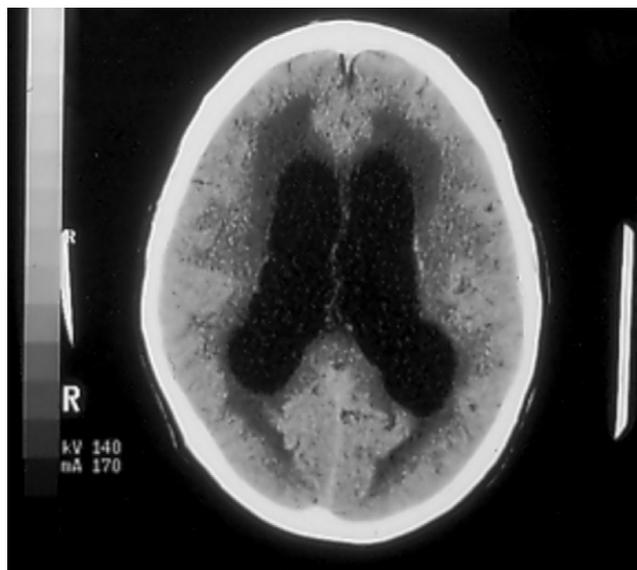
Radiographic demonstration of hydrocephalus in a patient with cryptococcal meningitis that presented with a syndrome consistent with normal-pressure hydrocephalus.
